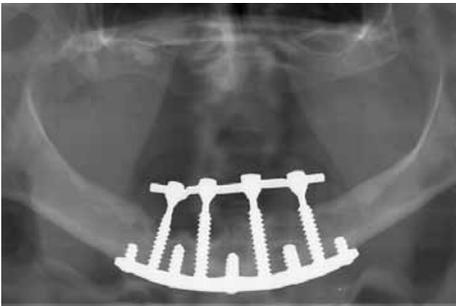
Panoramic radiograph showing extensive bone loss around 2 of the 4 transosseous posts.
